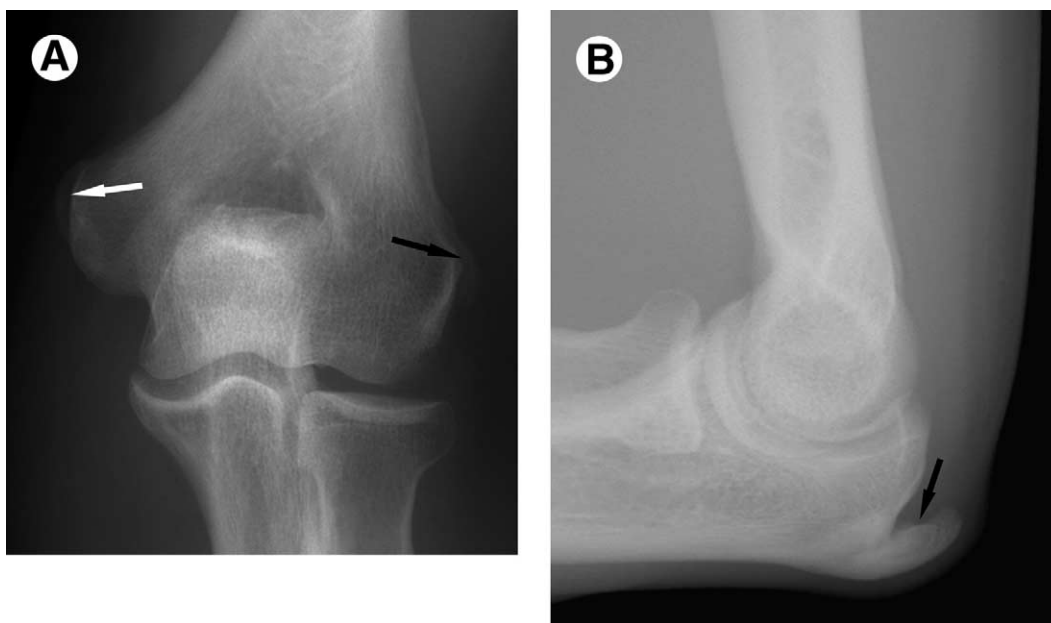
Enthesopathy. (A) Anteroposterior view demonstrates enthesophyte development along medial (white arrow) and lateral (black arrow) epicondyles. These changes occur at insertion sites of common flexor and extensor tendons, respectively. (B) Lateral radiograph in different patient reveals large enthesophyte (arrow) extending from posterior margin of olecranon process, at site of insertion of triceps brachii tendon.
